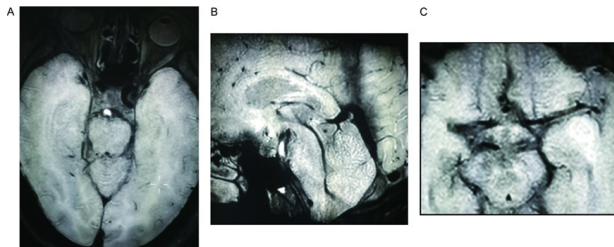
A: HR-VW-MRI sagittal view; B: HR-VW-MRI transverse view; C: HR-VW-MRI sagittal view. Note: A, B: Severe stenosis of the basilar artery lumen. C: Moderate stenosis of the left middle cerebral artery lumen.
